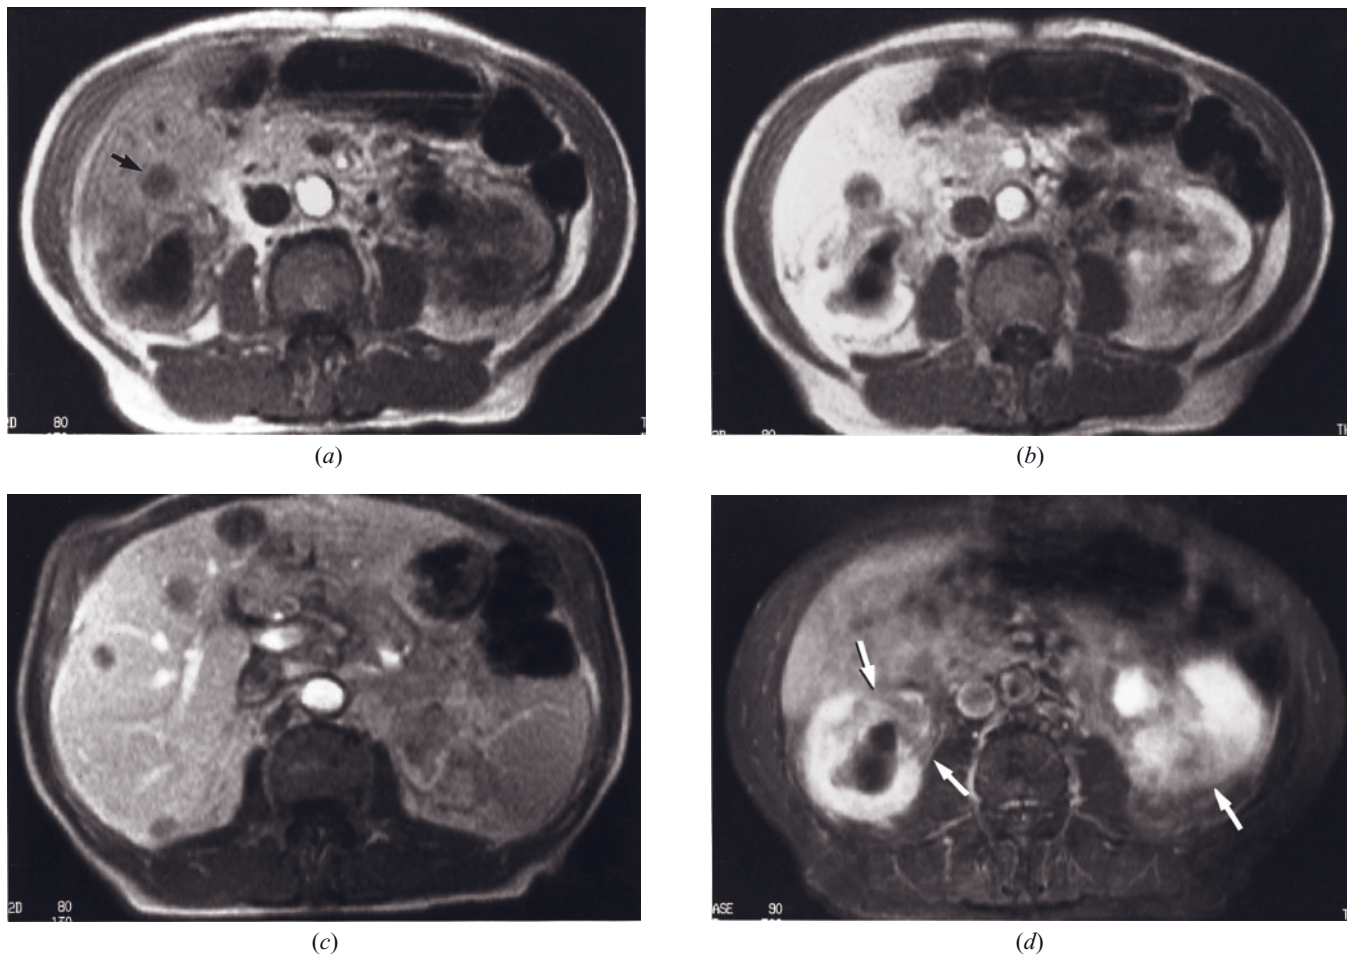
Transitional-cell carcinoma—Stage 4. T1-weighted precontrast SGE (*a*), immediate (*b*) and 90-s (*c*) gadolinium-enhanced SGE, and late-phase fat-suppressed postgadolinium SE (*d*) images. Bilateral infiltrative tumors are present arising from the collection system of both kidneys (*a*, *b*, *d*). The transitional-cell tumors are low in signal intensity on precontrast T1-weighted images (*a*), enhance minimally on immediate postgadolinium images (*b*), and show heterogeneous enhancement less than renal parenchyma on later images (arrows, *d*). Liver metastases are also present (*c*). Liver metastases from transitional cell cancer are generally hypovascular and are low in signal intensity on precontrast T1-weighted images (arrow, *a*), show faint rim enhancement on immediate postgadolinium images (*b*), and often remain well defined and hypointense on later postcontrast images (*c*). Liver metastases frequently are poorly seen on T2-weighted images (not shown) because of their hypovascularity.
